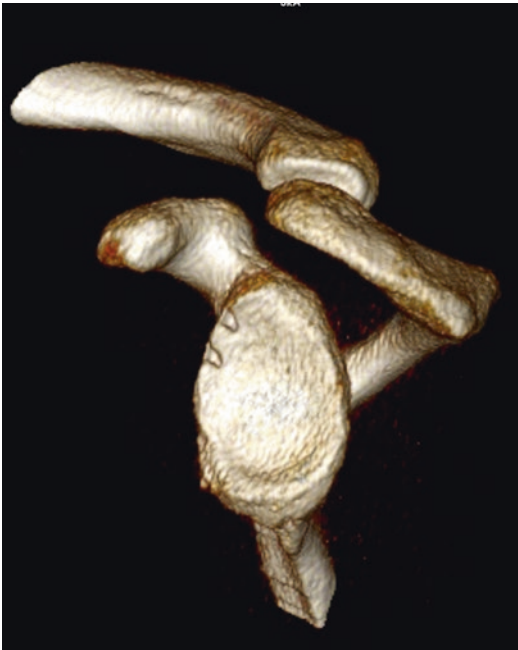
3D computed tomography of glenoid with anterior bone deficiency and failed arthroscopic Bankart repair. Clear malposition of the anchors in the anterosuperior margin of glenoid
